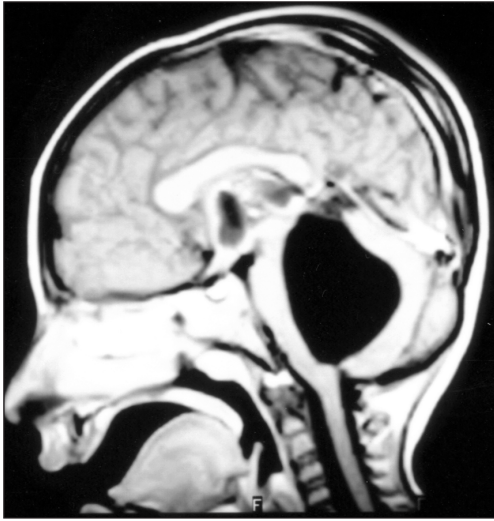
Sagittal T1-weighted magnetic resonance image shows the dilatation in the 4th ventricle.
